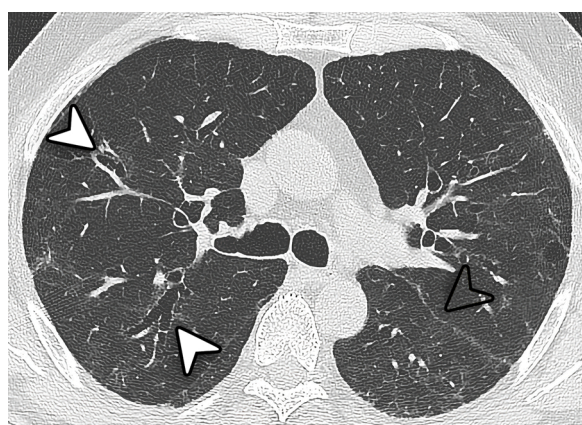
Unenhanced chest CT scan of an 82-year-old man who suffered severe COVID-19. The examination was performed 98 days after the disease onset. Axial image shows central bronchial dilatations (white arrowheads) and scissural distortion (empty arrowhead). Reticulation coexisted in both lungs.
